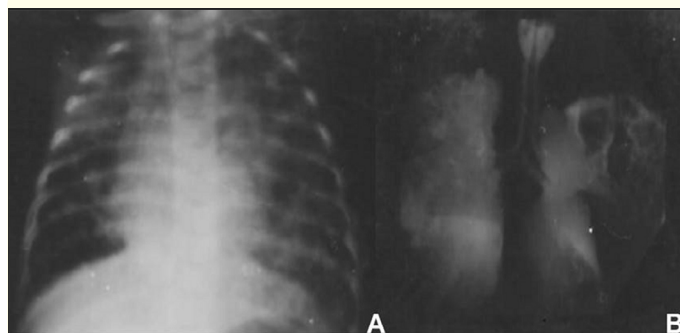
(Plain radiographs) A: Chest images indicative of tuberculous dissemination, mainly on the middle and upper thirds of the left lung with bullae; and B: Images of autopsied tracheobronchial tree and lung bloc, confirming the presence of multiple cavities.
